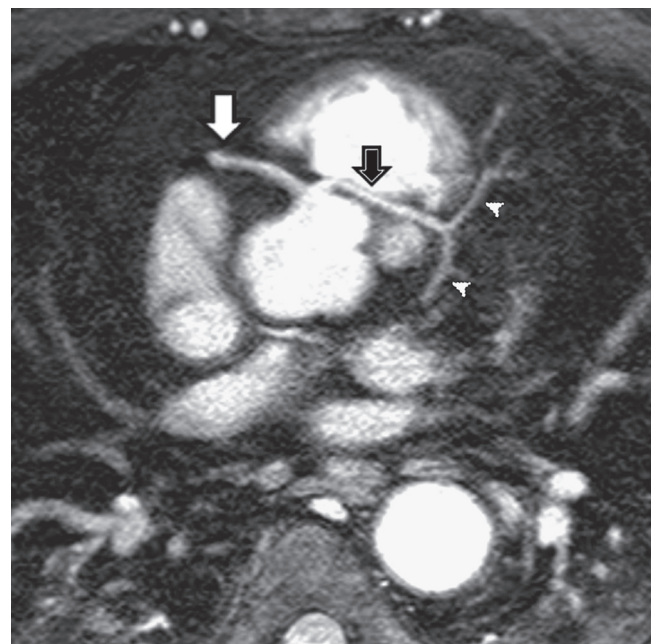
■ Anomalous coronary artery. The three-dimensional coronary cardiovascular magnetic resonance image reformatted in the axial plane indicates an anomalous origin of the left main coronary artery (black arrow) from the right sinus of Valsalva. The left coronary artery courses between the aorta and the main pulmonary artery (malignant form) before bifurcating into the left anterior descending and left circumflex arteries (arrowheads). The right coronary artery (white arrow) originates normally from the right sinus of Valsalva.
